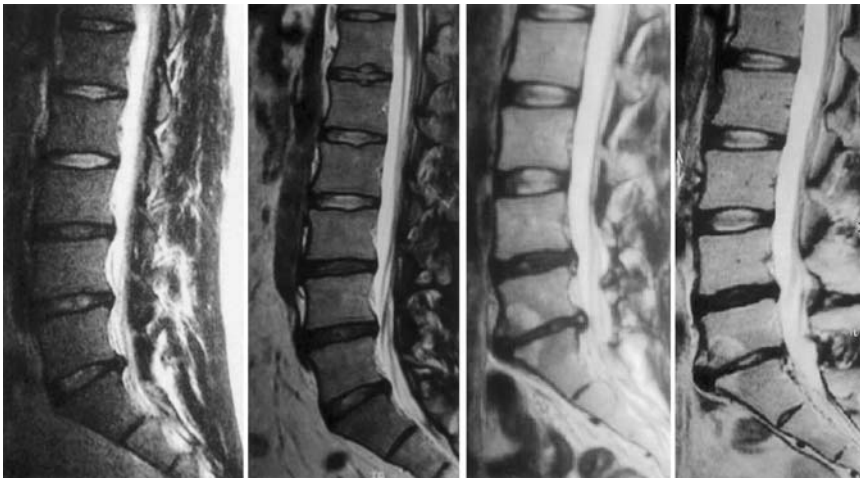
Magnetic resonance images obtained before and after IDET in the same patient (sagittal T2 images). Case 1 (left two panels): pre-IDET (left), six months post-IDET (right). Case 2 (right two panels): pre-IDET (left), six months post-IDET (right)
